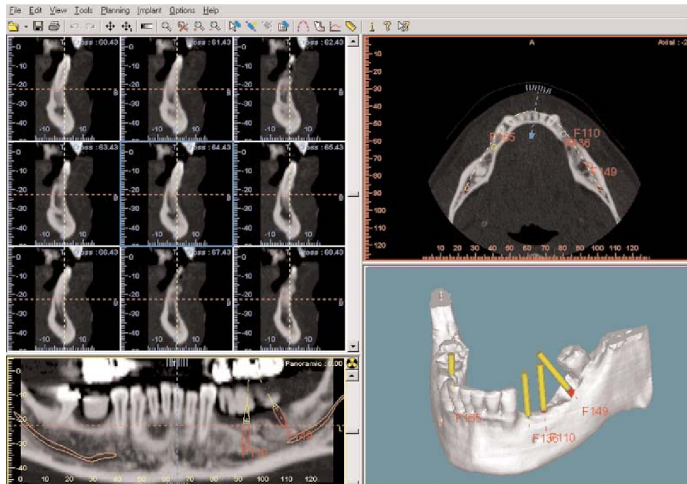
CT imaging used to evaluate bone density, quality, contour and volume. (10)
